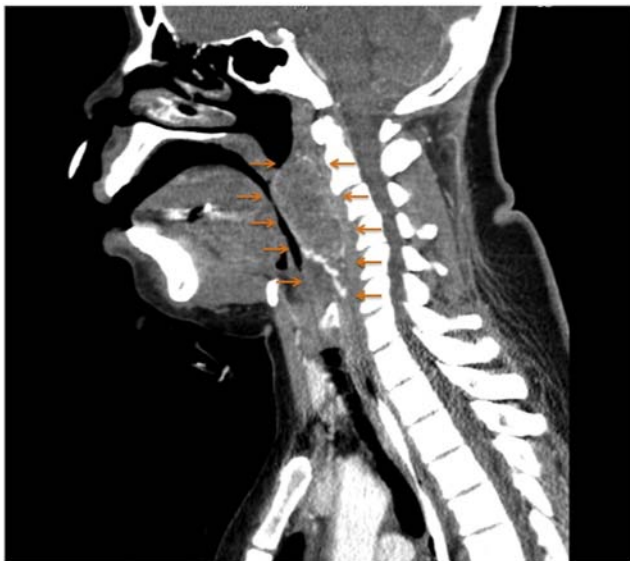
Computed tomographic sagittal image shows a 7.2-cm oropharyngeal mass (arrows) with curvilinear calcifications with focal extension into the retropharyngeal/parapharyngeal space.
